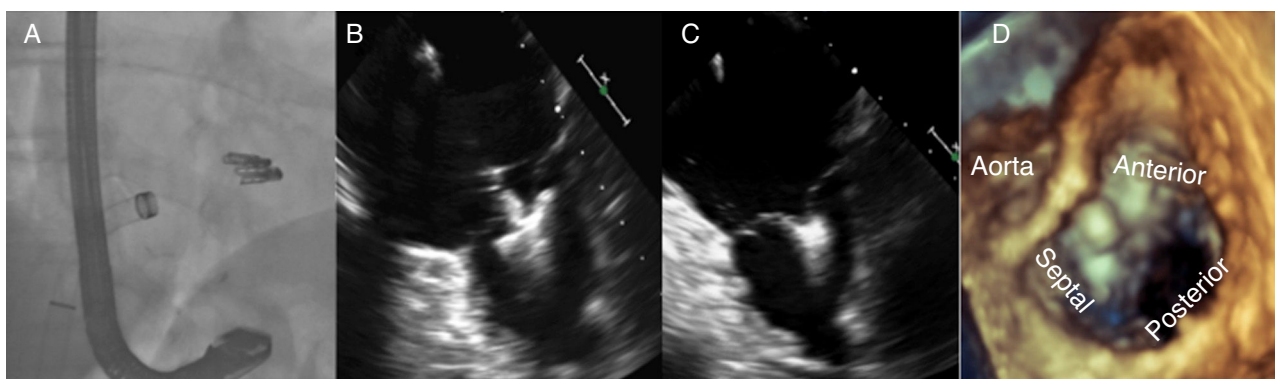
Fluoroscopy image sequence and TEE during the procedure. A: final position of the clips on fluoroscopy. B and C: 2D-TEE image at 0° with the clip open and closed after the attachment of the anterior (left) and septal (right) leaflets. D: 3D-TEE image showing the final position of the second clip between the anterior and septal leaflets. 2D, 2-dimensional; 3D, 3-dimensional; TEE, transesophageal echocardiography.
